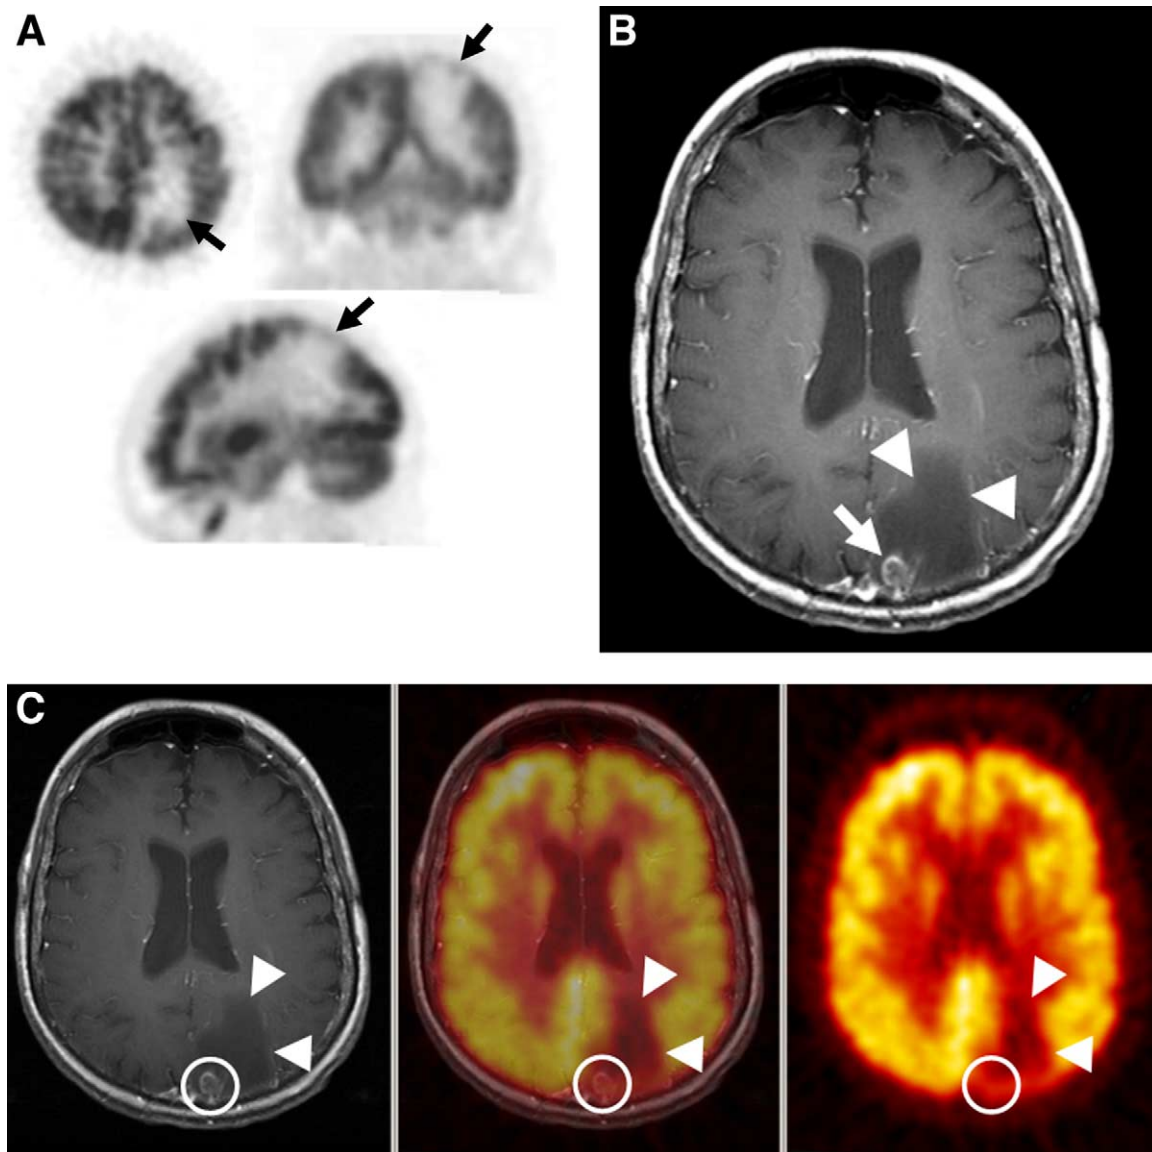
FDG-PET and cerebral metastases. A 68-year-old subject with newly diagnosed NSCLC. (A) Axial, coronal, and sagittal images of the brain from an FDG-PET scan showing a large region of photopenia involving the left parietal lobe (arrows). In a patient with malignancy, metastatic disease must be considered. However, stroke or other vascular disease could also cause this appearance. (B) Axial T1-weighted MR image obtained after intravenous administration of gadolinium, showing a small cortical metastasis in the medial parietal lobe on the left (arrow). There is extensive vasogenic edema (arrowheads) adjacent to the metastasis. (C) Surface-matched fusion images of the contrast-enhanced MR and FDG-PET studies. The location of the left parietal metastatic lesion is circled on each image. On the PET image, the metastatic lesion is hypometabolic compared with normal cerebral cortex, and is not visible as a discrete abnormality. The large region of hypometabolism seen on the initial brain images corresponds to the extent of vasogenic edema (arrowheads).
